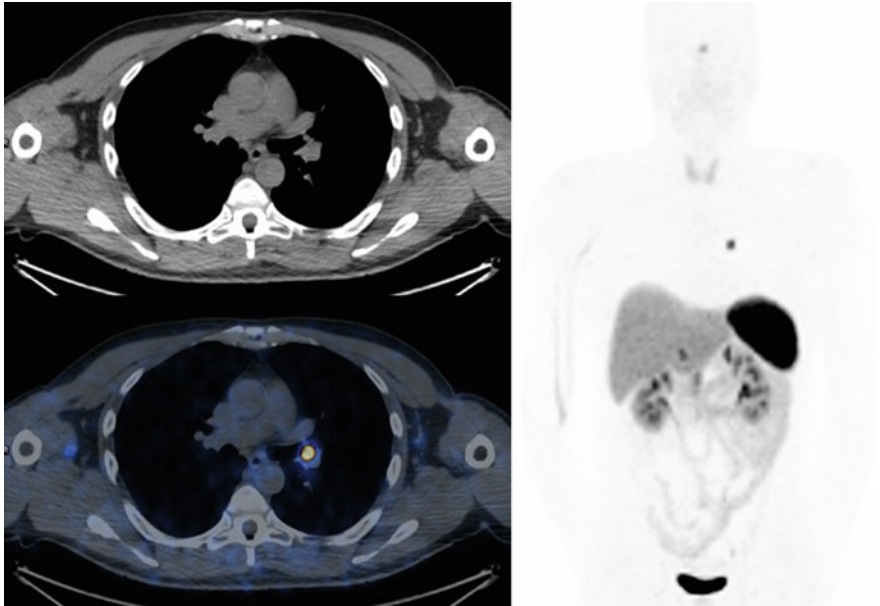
MIP image of ^{68}Ga -DOTATOC PET/CT (right-sided panel of the figure), with transversal images of the pathological lesion in the left bronchus corresponding to a pulmonary neuroendocrine tumour; note the appearance of the small tumour detectable on localization CT as endobronchial nodule
